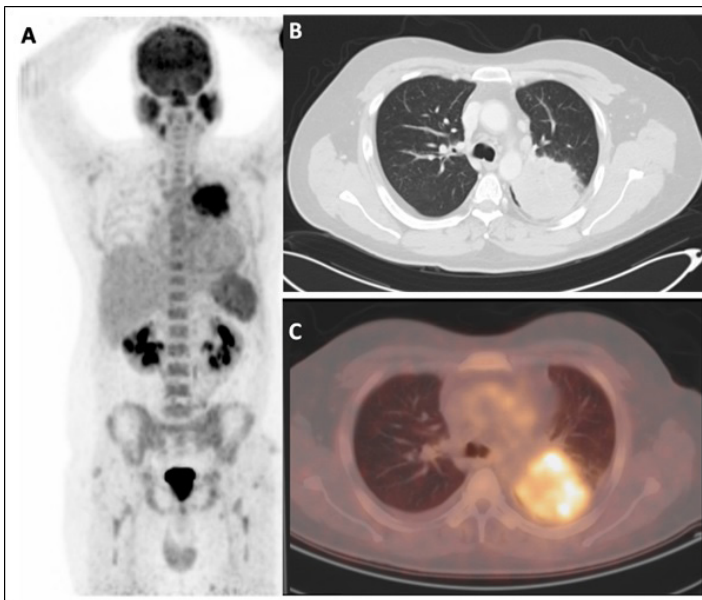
CT (B) showing large left upper lobe enhancing pulmonary mass with high FDG uptake on PET/CT (A, C) [25].
